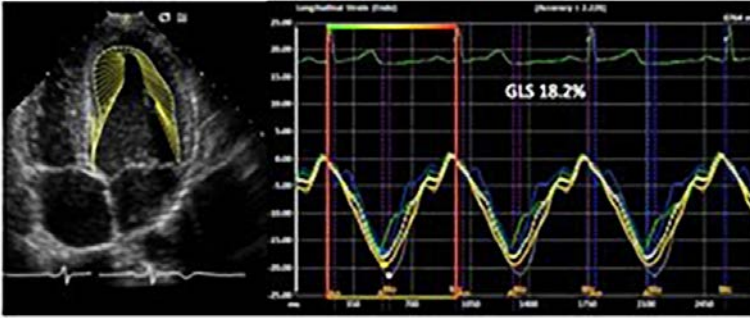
Speckle tracking echocardiography. (Left) Velocity vector imaging, which is a speckle tracking algorithm. The vectors in yellow represent the deformation of the myocardium in systole. The length of the vectors correlates with the magnitude of deformation and the direction of the arrows represents the net direction of myocardial deformation (longitudinal, circumferential, radial). (Right) The curves show data for longitudinal deformation for three cardiac cycles and the average longitudinal deformation. The global longitudinal strain is 18.2%.
